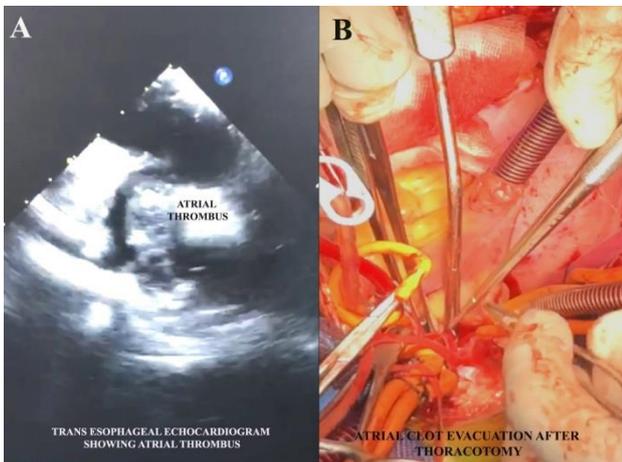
(A) Intraoperative transesophageal echocardiogram showing thrombus in right atrium. (B) Thoracotomy and atrial clot evacuation.
